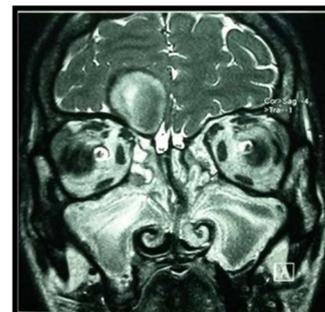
Coronal T2-weighted MRI showing a fronto-ethmoidal sinus mucocoele with endocranial extension.
